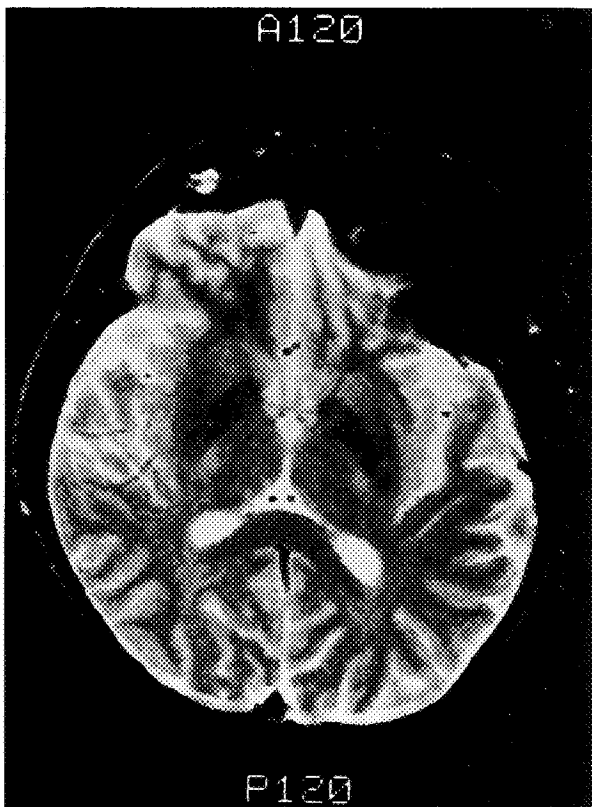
T2-weighted image of Patient 1. Affected bone shows low signal intensity.
